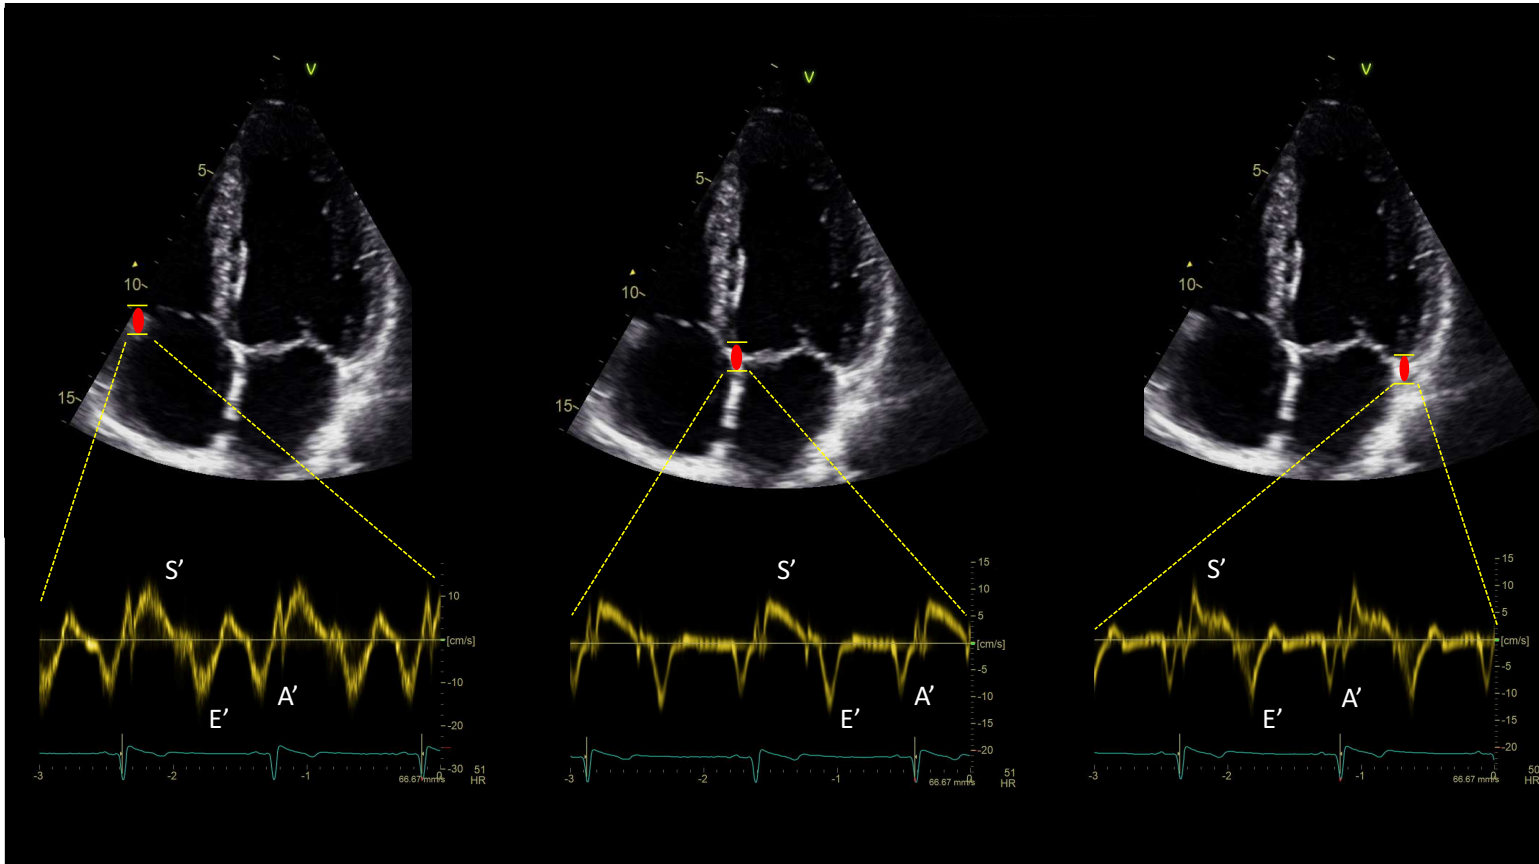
Tissue Doppler imaging of the right ventricular free wall, septal mitral annulus and lateral mitral annulus (left to right), for S', E' and A'.
